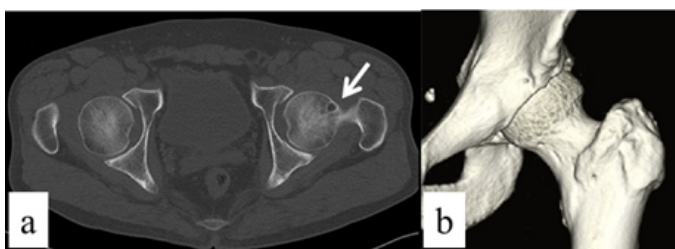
Plain computed tomography. (a) Axial view. The white arrow indicates a bone cyst, (b) 3D view. A bump formation was observed in the femoral neck.
